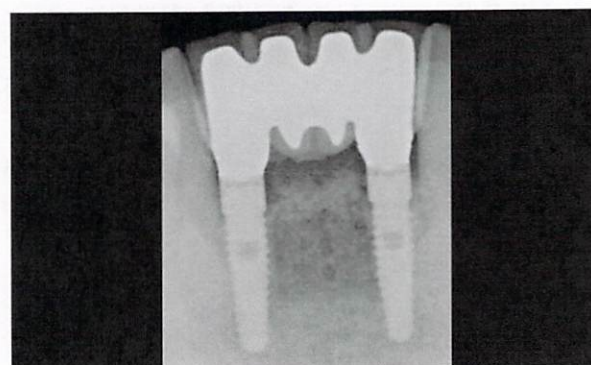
The 4-year postoperative radiograph.
